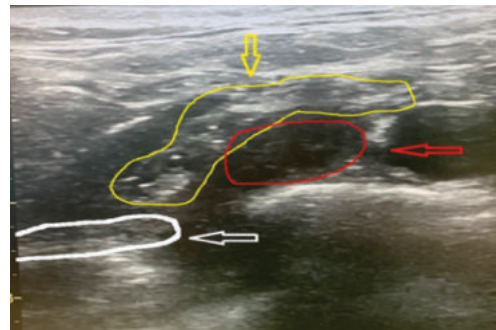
Ultrasonography image during BPB.
